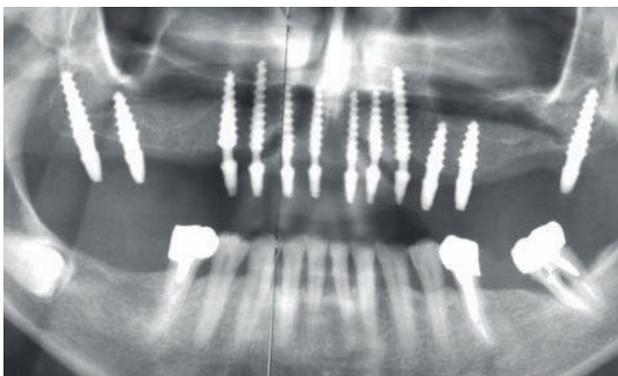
Radiograph taken immediately after implant insertion.
